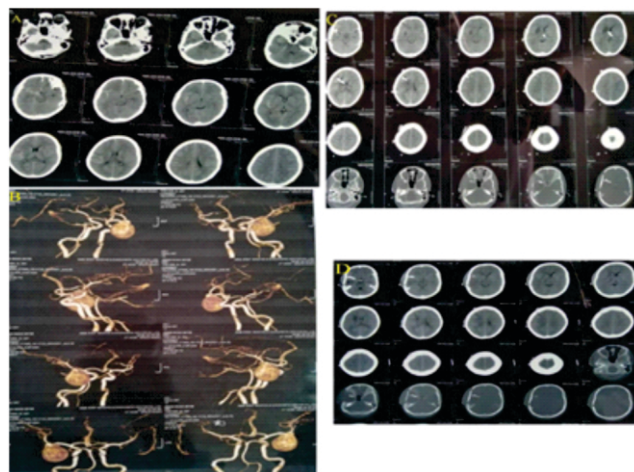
Preoperative axial CT image showing basal cistern and right sylvian fissure subarachnoid hemorrhage (A), Preoperative cerebral 3D CT angiography image showing giant saccular aneurysm of M1 segment of right middle cerebral artery (B), Postoperative axial CT image showing EVD in situ and right basal ganglian region hypodense area (C) and Postoperative axial CT image showing improved in hypodense area at the follow up time (D).
